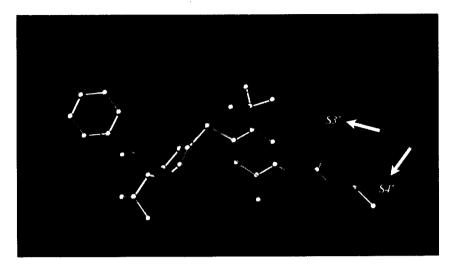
Molecular model of 29 docked in the HIV PR (green) X-ray structure. The S₃' and S₄' subsites are highlighted. The atoms of the inhibitor are colored by atom type (C-white, H-cyan, O-red, N-blue, and S-yellow).
